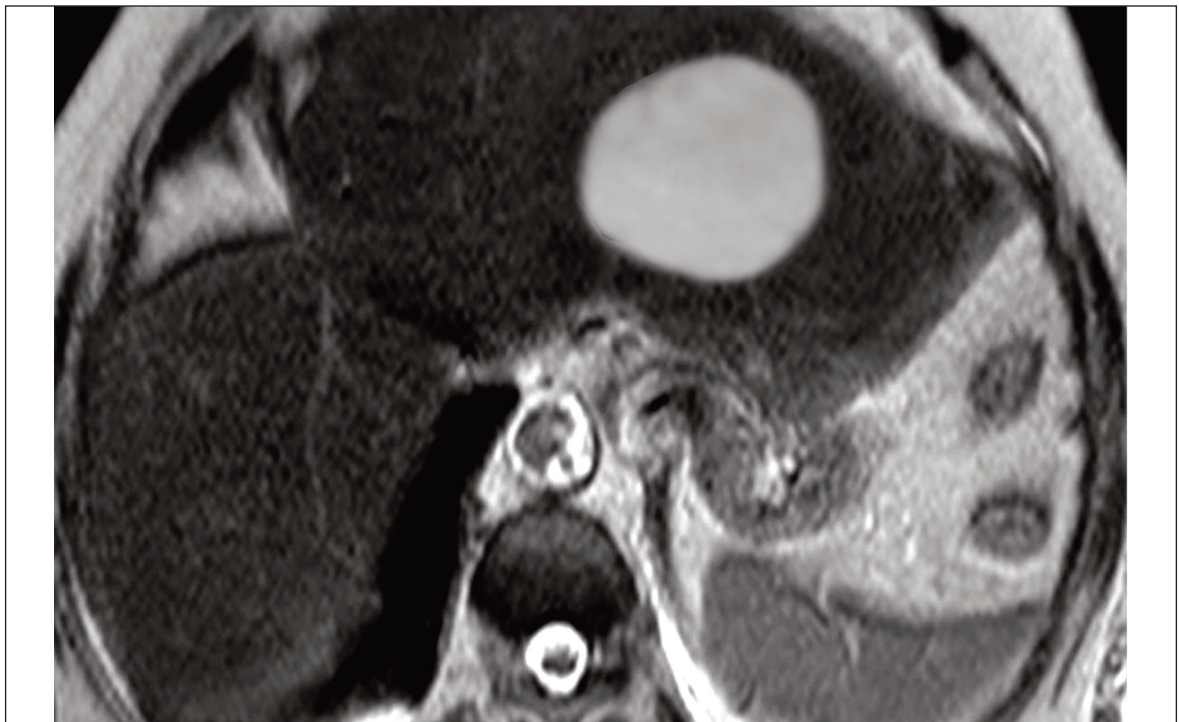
Axial T2-weighted Magnetic Resonance Imaging (MRI) image: simple liver cysts.
